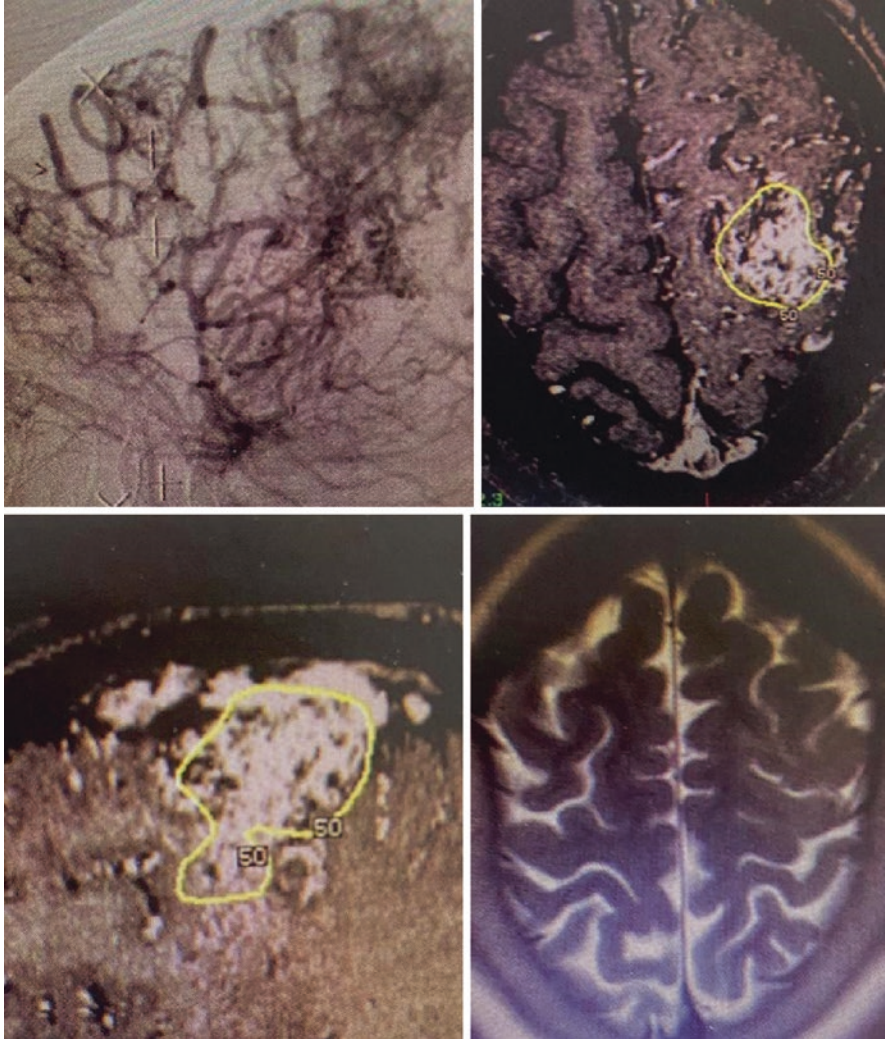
This is a 13-year-old girl who was experiencing right arm and leg tingling episodes and headaches, found to have a moderate sized left frontal AVM with partial moyamoya disease (a: the AVM and moyamoya on lateral left carotid angiogram). Gamma Knife was performed (b: axial postcontrast T1 MRI from date of treatments; c: sagittal postcontrast T1 MRI from date of treatment). MRI from 6 years later shows complete resolution of the AVM (d: axial postcontrast T1 weighted MRI). Her symptoms have all resolved
